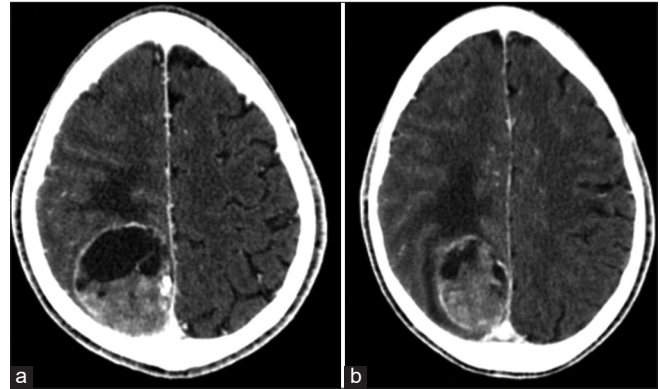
A contrast-enhanced axial brain computed tomography image (a and b) showing a right parieto-occipital lesion, well-demarcated, and enhanced capsule consisting of solid and cystic parts with perifocal edema and subtle midline shift to the left.
